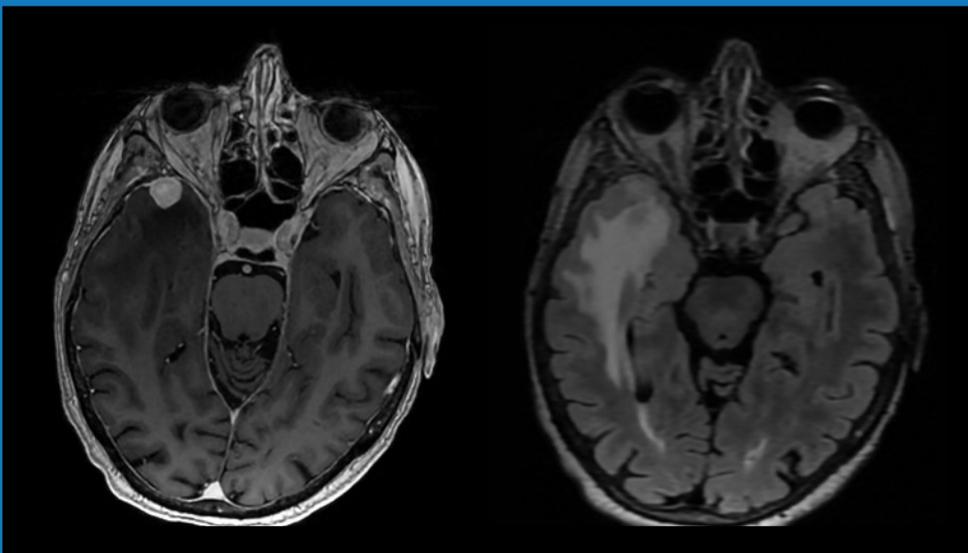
(Left) Axial T1-weighted MRI with gadolinium demonstrating an enhancing extra-axial lesion in the right middle fossa. (Right) Axial FLAIR MRI showing extensive peritumoral vasogenic edema.
